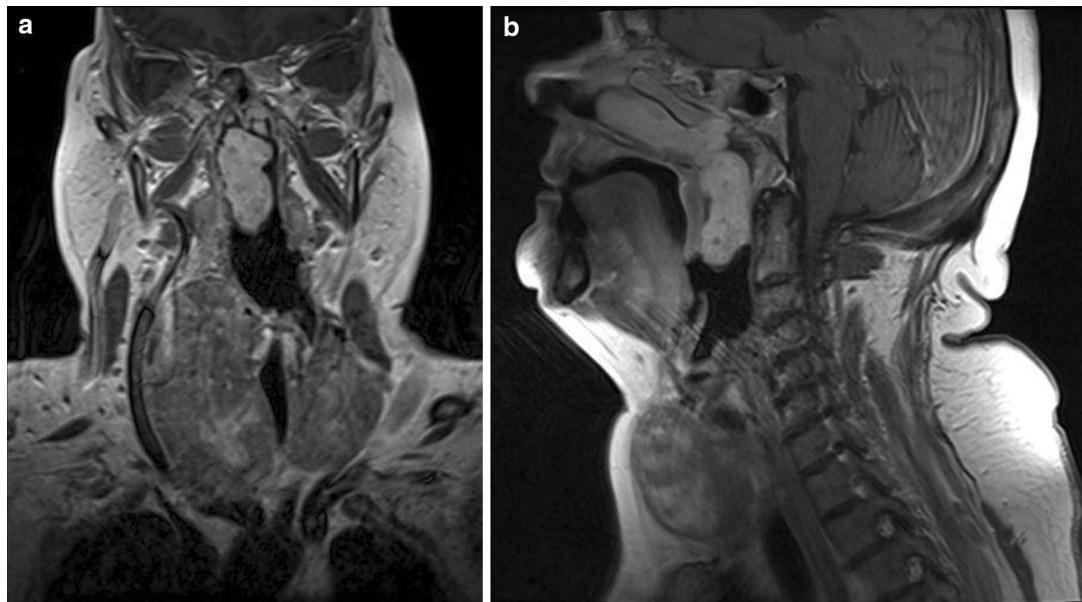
Computed tomography identifying the nasopharyngeal haemangioma: a coronal section, b sagittal section
